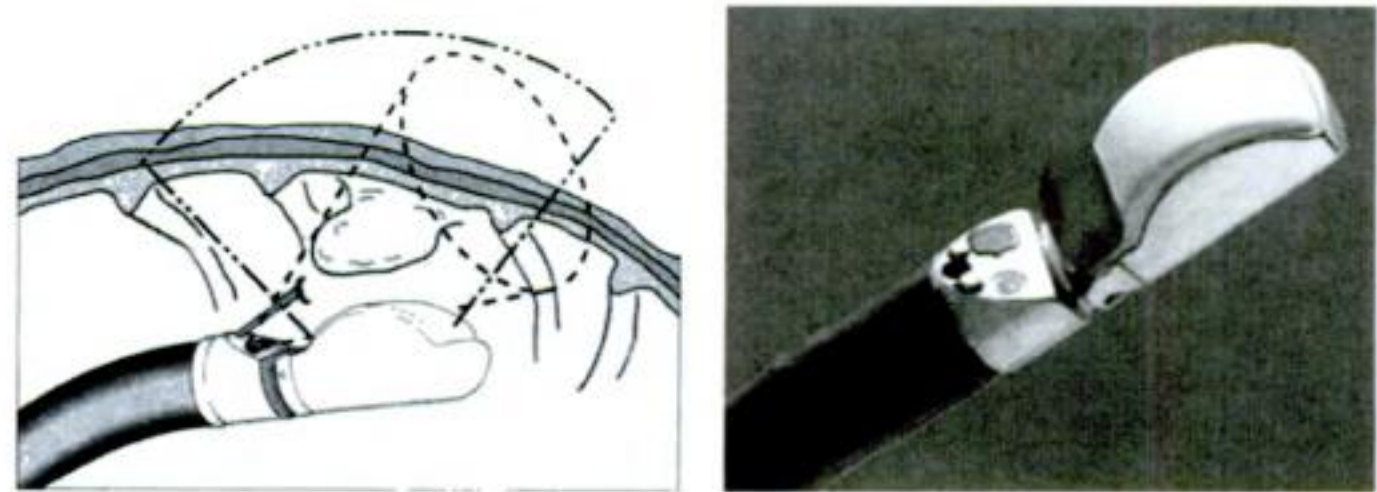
Ultrasound endoscopy linear array Pentax system.
